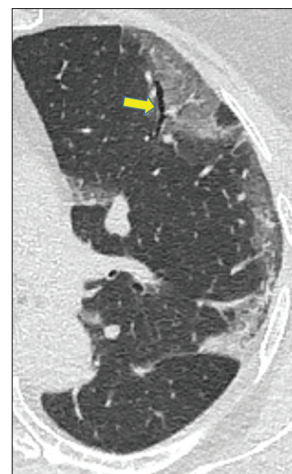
A 70-year-old male coronavirus disease 2019 patient. A computed tomography scan shows ground-glass opacity in the left upper lobe with bronchial dilatation (yellow arrow)
